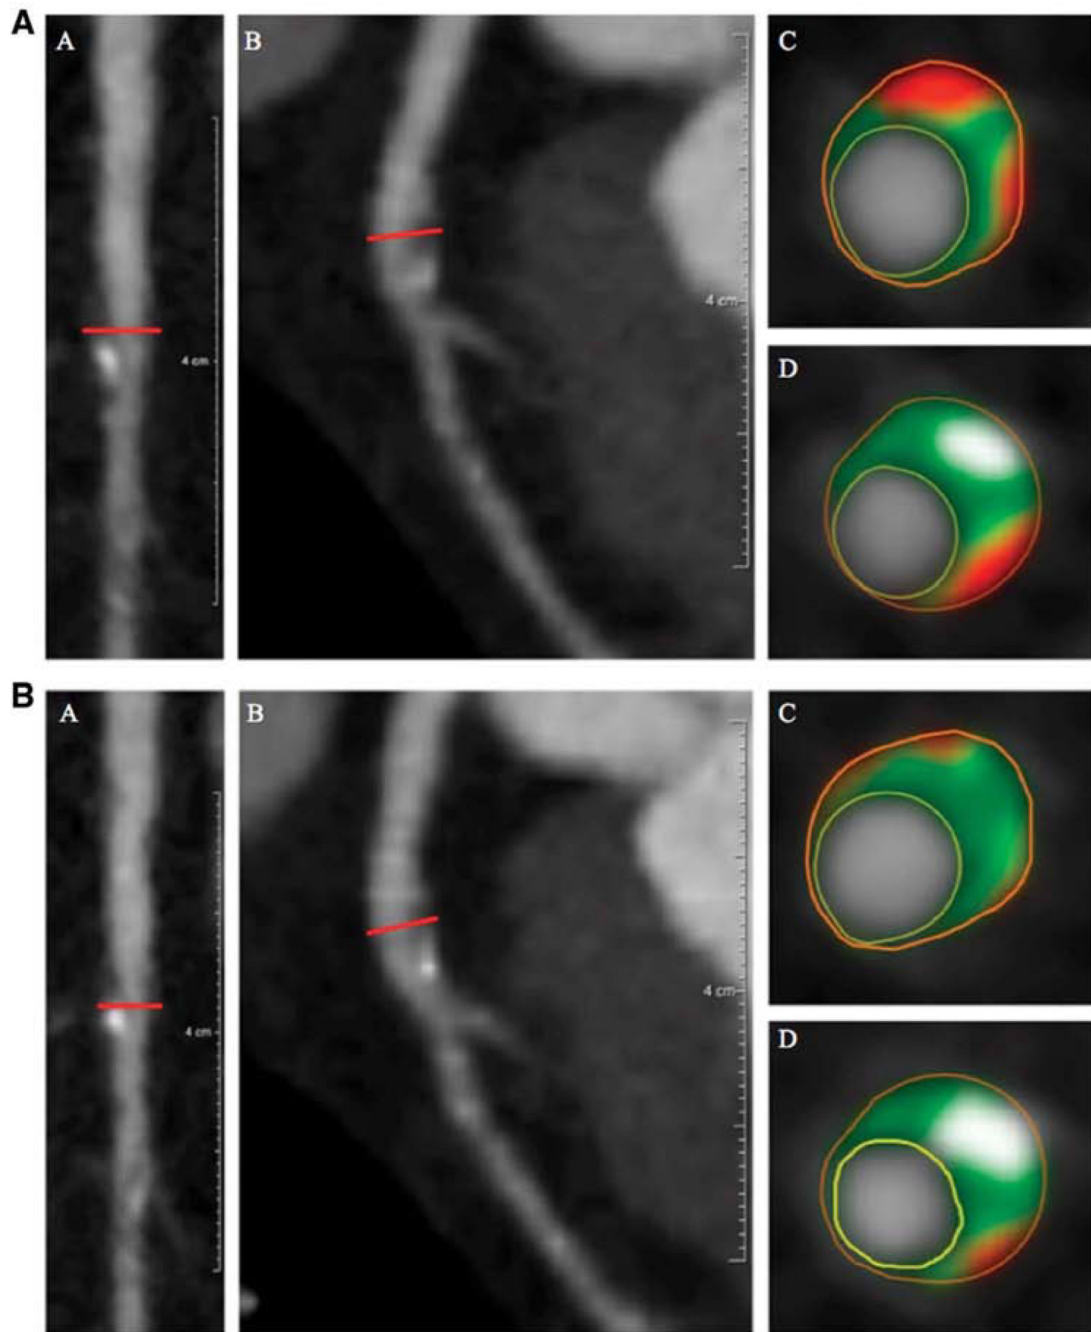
Coronary computed tomography angiography demonstrates favorable modulation of coronary plaque characteristics in response to treatment with biologic therapy in psoriasis.
